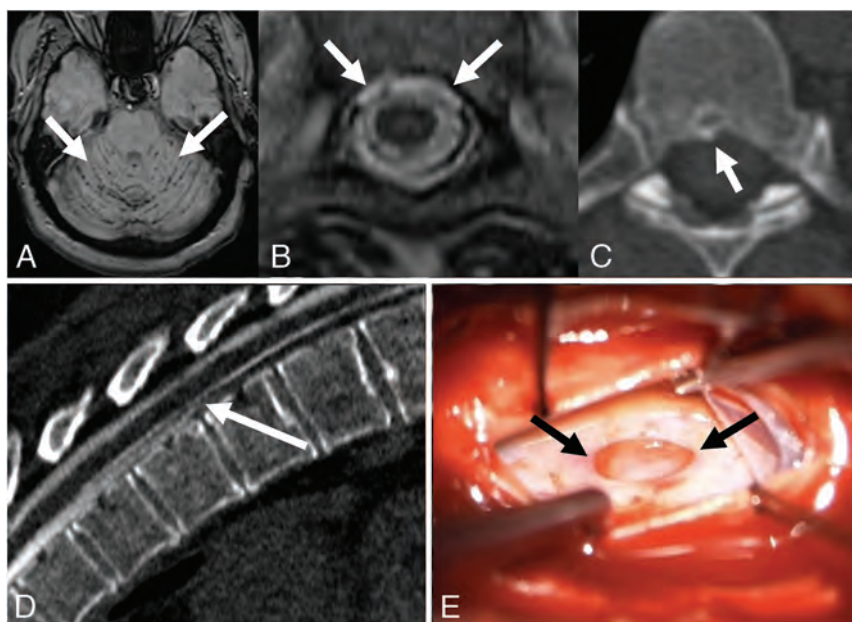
A 49-year-old man with a history of spontaneous intracranial hypotension, with persistent symptoms after 3 epidural blood patches. *A*, Axial SWI with hypointense signal along the cerebellar folia (arrows), consistent with superficial siderosis, a rare complication of chronic CSF leak. *B*, Axial T2-weighted MR imaging demonstrates a ventral epidural fluid collection (arrows). *C*, Axial noncontrast CT image shows a small osteophyte (arrows) along the ventral canal at T6–7. *D*, Prone dynamic CTM demonstrates extravasation of contrast from the subarachnoid space into the ventral epidural space at T6–7 (arrows), consistent with a ventral dural defect. *E*, Intraoperative photograph during repair of the ventral dural defect (arrows) at T6–7, accessed via hemilaminectomy, posterior durotomy, and lateral mobilization of the cord after dentate ligament resection.
